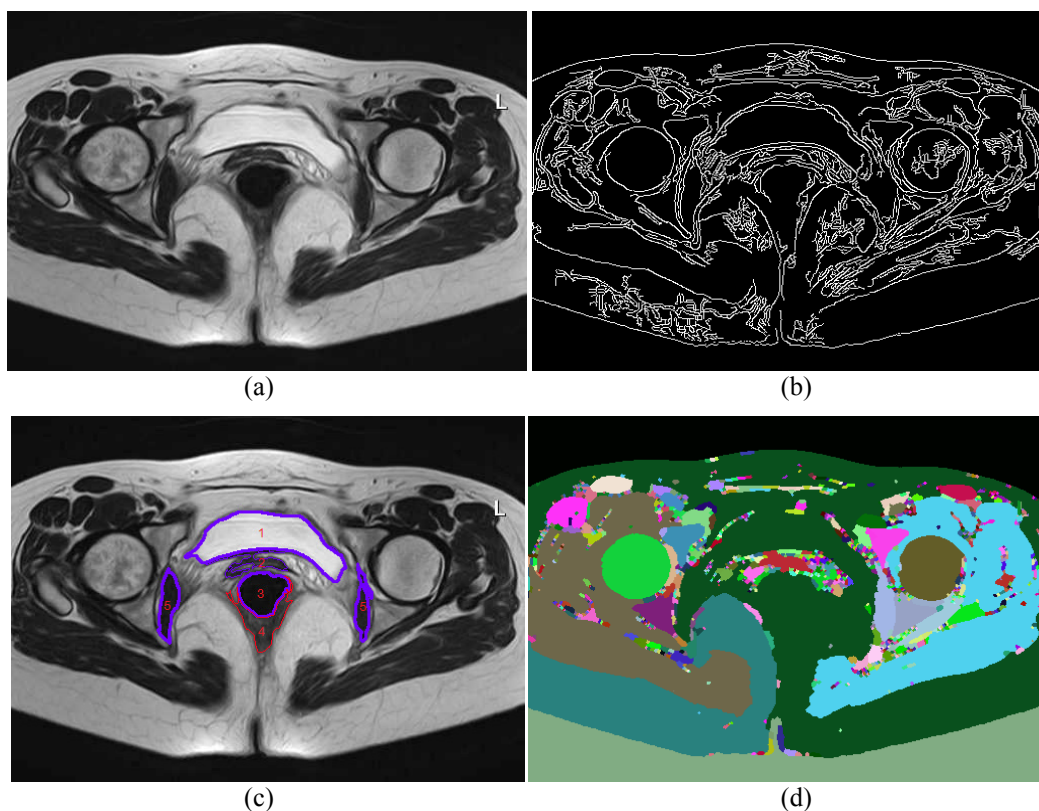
(a) MR image of the pelvic cavity; (b) Canny edge detection; (c) Region growing algorithm: 1-bladder; 2-vagina; 3-rectum; 4-levator ani; 5-obturator internus; (d) Watershed algorithm.
